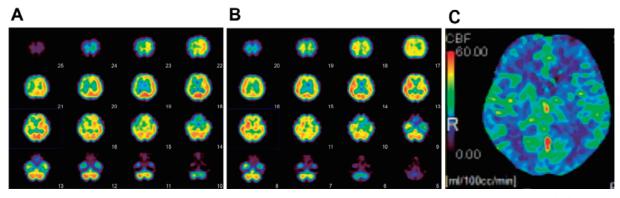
N*-Isopropyl-*p*-[¹²³I] iodoamphetamine single-photon emission computed tomography (¹²³I-IMP SPECT). (A) Preoperative ¹²³I-IMP SPECT showing widespread reduction in the cerebral blood flow (CBF) (blue) in the right hemisphere. (B) Emergency ¹²³I-IMP SPECT performed on postoperative day 1 showing widespread CBF elevation (red) in the right hemisphere. (C) CT perfusion performed on postoperative day 3 showing no CBF laterality.
